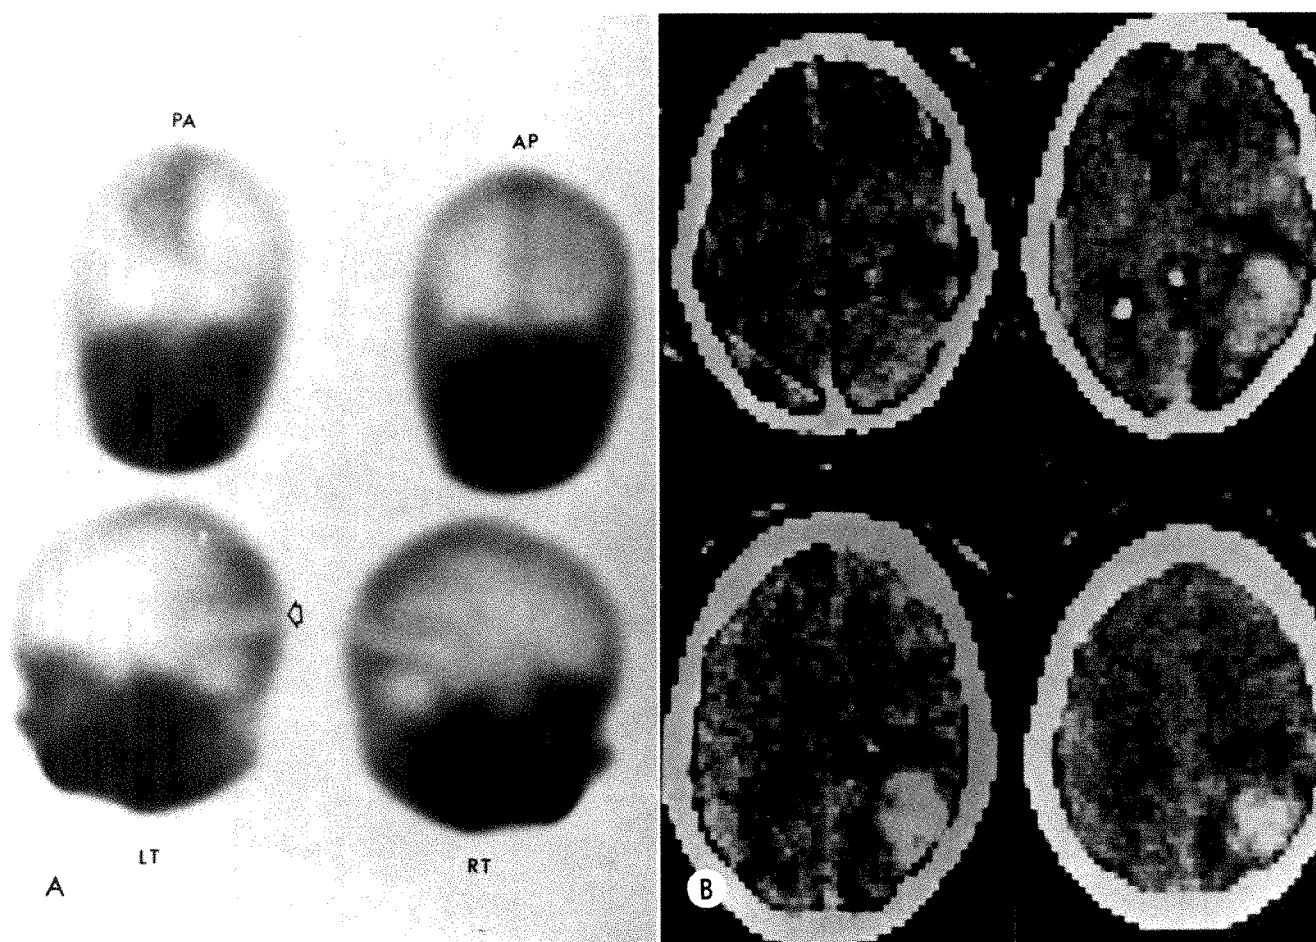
56-year-old man with surgically proven glioma. *A*, Static radionuclide scan demonstrating area of increased uptake in right occipital region, separate from tentorium (arrow). Absence of tentorial confluence suggests lesion other than infarct. *B*, CT scan following intravenous infusion of contrast material showing right parietooccipital mass.
